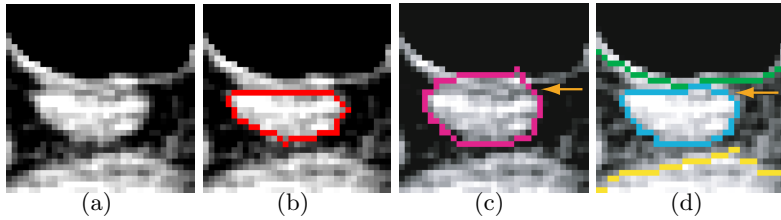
Feasibility examples of lymph node segmentation in X-ray CT data. (a) One 2-D slice from 3-D CT image. (b) Manual segmentation of lymph node boundaries. (c) Segmentation failure resulting from the conventional graph-cut method. (d) Simultaneous region–surface segmentation of the lymph node (blue) and surrounding tissues (green and yellow) using our new approach showing excellent segmentation performance. The improvement is indicated by the arrow.
